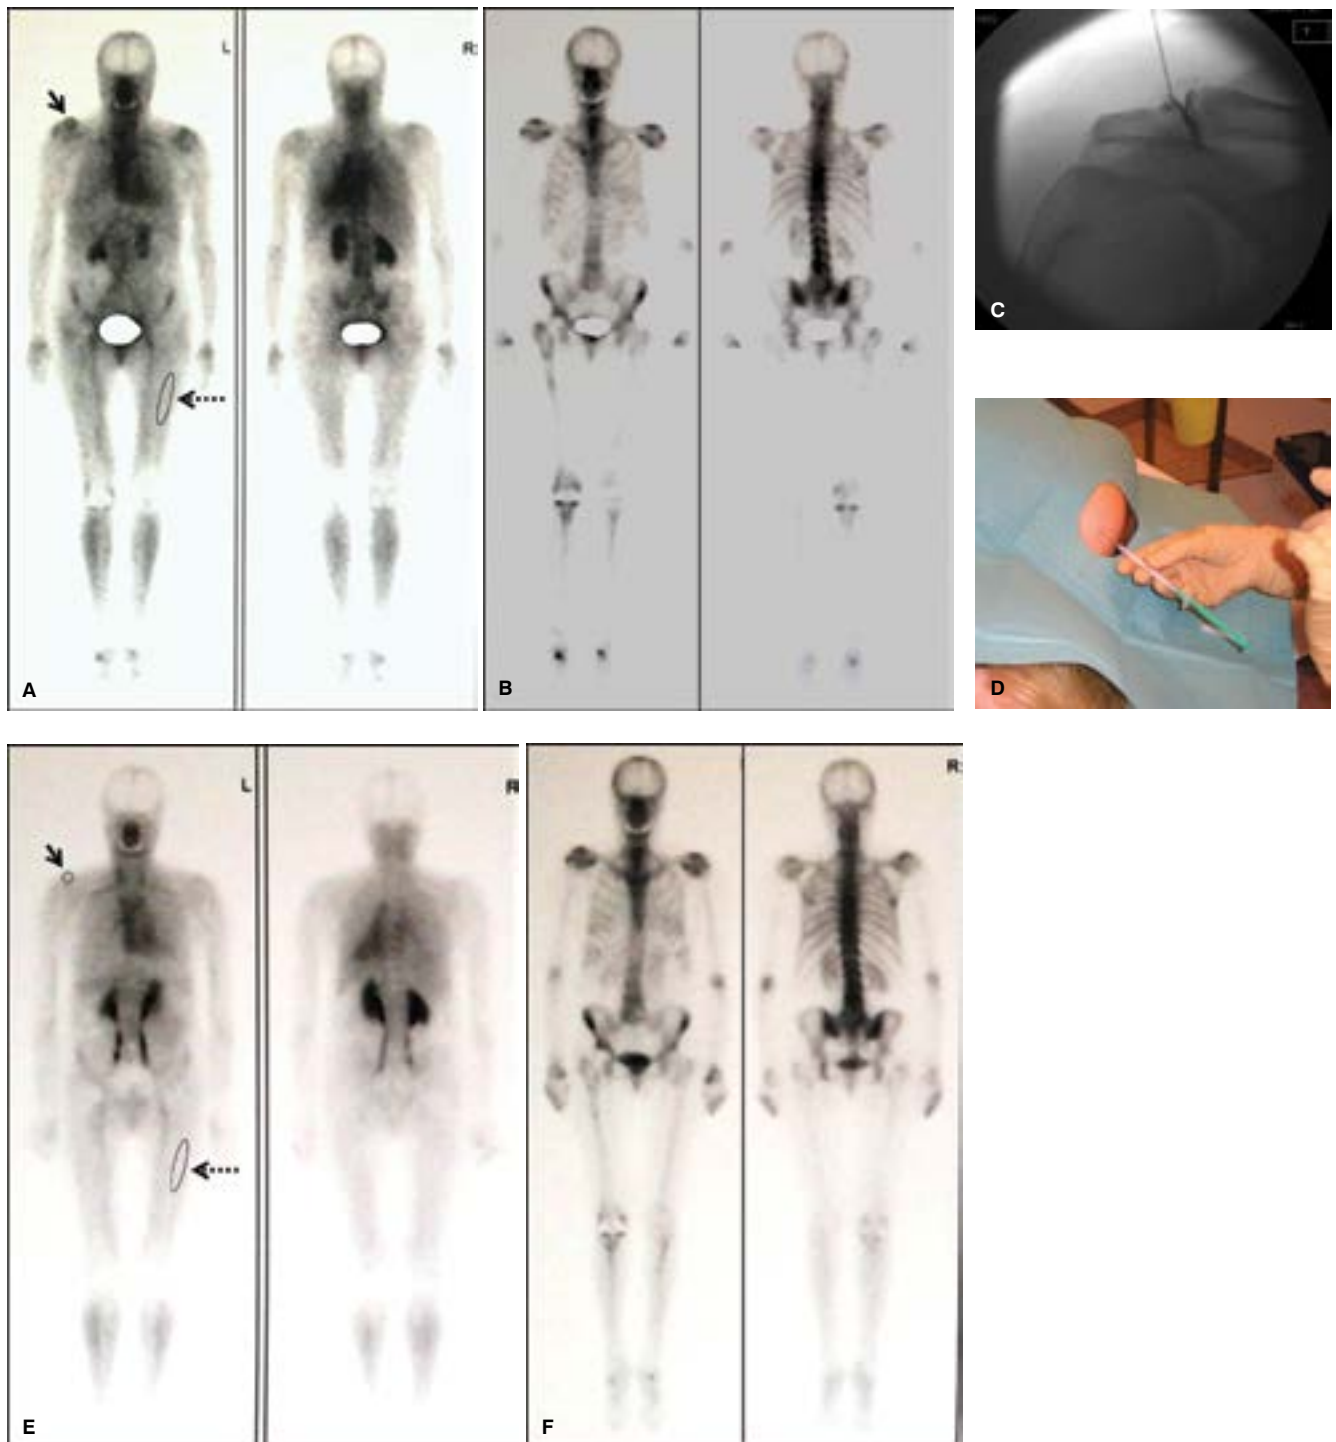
A case of 58-years old female patient with polyarthritis. Two-phase bone scintigraphy with 519 MBq of ^{99m}Tc -metylenbisphosphonate including blood pool imaging phase (A) and bone phase (B); Whole body anterior (left) and posterior (right) views confirmed increased blood pool and increased osteoblastic activity in both AC (more pronounced on the right side), both I. carpometacarpal joints and in metatarsophalangeal joints on both sides; prosthesis of right hip and right knee. The RSO of right AC joint was indicated. After intraarticular instillation of 0.1 mL of contrast agent to confirm optimal needle position (C) the syringe was changed and ^{169}Er -citrate was administered into articular cavity (D). After next change of syringes, the needle was flushed by 0.1 mL of triamcinolone 20 mg/mL. Six months after RSO of right AC joint the patient reported decrease in VAS from 8 to 2 and global effect of treatment was ranked as excellent. Follow-up two-phase BS was performed 6 months after treatment: BPI phase (E) and bone phase (F); Whole body anterior (left) and posterior (right) views. For calculation of target/non target ratio, the circular region of interest was drawn in the area of increased tracer uptake in the area of AC joint (target) (A, E arrow) and elliptical region of interest (non-target, background) (A, E dashed arrow) covering approximately medial third of soft tissues of the left femur, avoiding area of large vessels was drawn, both on planar anterior view of BPI. On semiquantitative assessment of blood pool perfusion of AC joint prior and after RSO the target/non target ratio decreased from 1.39 to 1.14 (by 17%). Persistent osteoblastic activity in both acromioclavicular joints (B, F), still more pronounced on the right side
